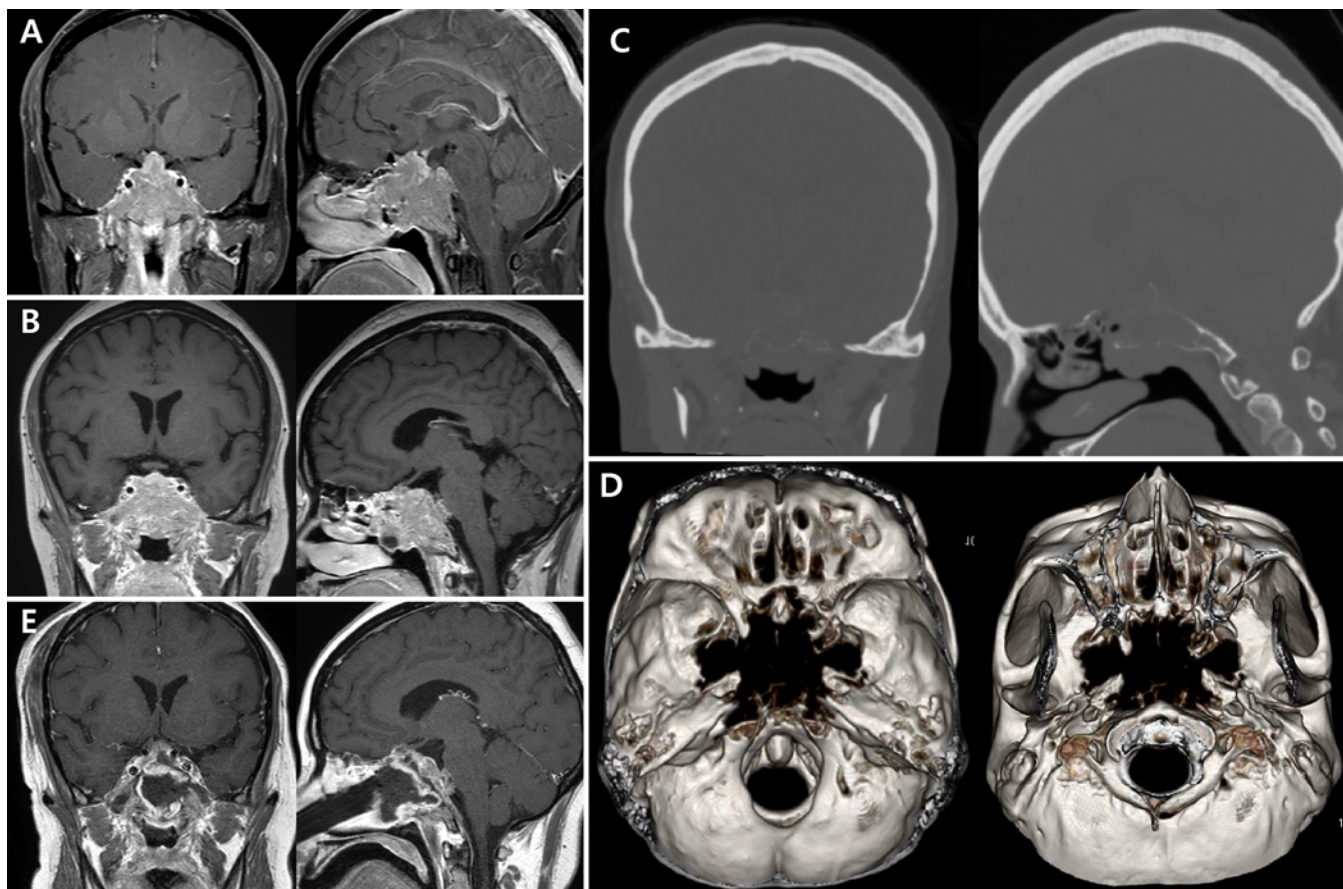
Case 3. A: Coronal and sagittal T1-weighted contrast-enhanced MR images obtained before undertaking the transcranial approach. B: After partial removal of tumor via a transcranial approach was performed to decompress the optic nerve, CSF rhinorrhea developed. C: Coronal and sagittal CT scans demonstrating extensive skull base destruction by tumor invasion. D: 3D reconstruction images of CT scans showing a wide defect of skull base bony structure including sella, parasellar area, frontal base, left temporal base, left sphenoid wing, and clivus. E: Coronal and sagittal MR images obtained at 3 months, showing successful reconstruction with an extended nasoseptal flap including the whole lateral nasal wall mucosa (360° flap). Figure is available in color online only.
